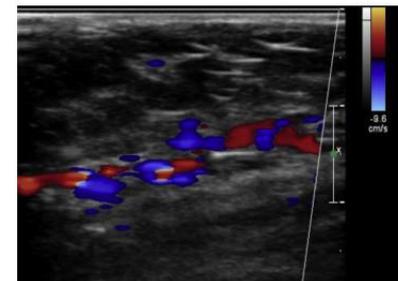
Neovascularization (blue and red) around a previously ligated saphenofemoral junction of a patient with recurrent varicosities on color duplex ultrasonography.
